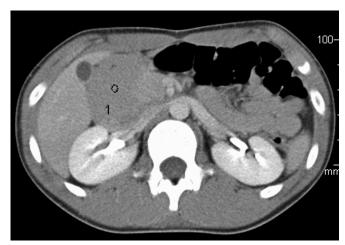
Computed tomographic scan of abdomen depicting right-sided abdominal mass.
